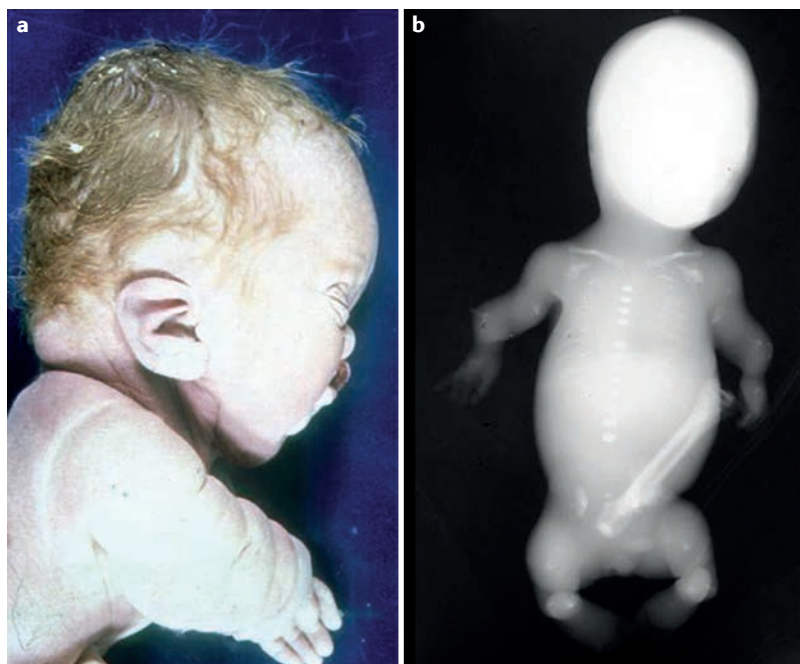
Perinatal hypophosphatasia. a | Stillborn neonate showing profound deformities that cause accordion-like skinfolds of the arm, which are explained by lack of underlying bony structure. b | Almost no mineralization of the skeleton is revealed by radiographic examination.
